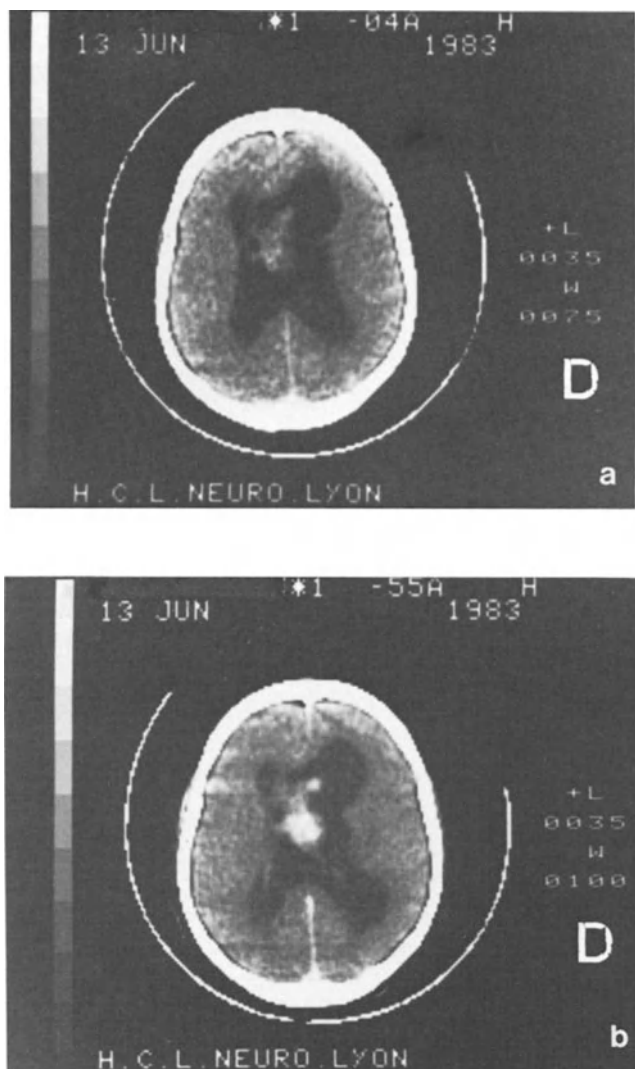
Grade I septal astrocytoma. a) Pre-contrast CT. b) Post-contrast CT
